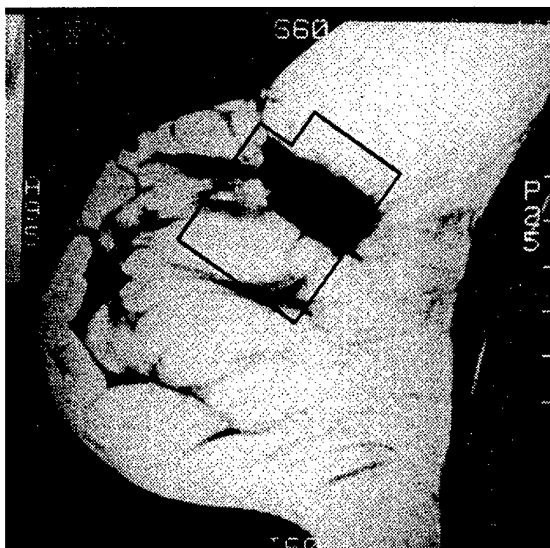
MRI (lateral slice) of case 1, whose cancer was removed (lumpectomy) one month previously. This MRI was taken prior to radiation therapy (pre-radiation). The closed area shows the area where optical imaging was conducted (see Figure 3). Also note that a 2 x 1.5 cm seroma is seen in the location where the lumpectomy had been performed.
